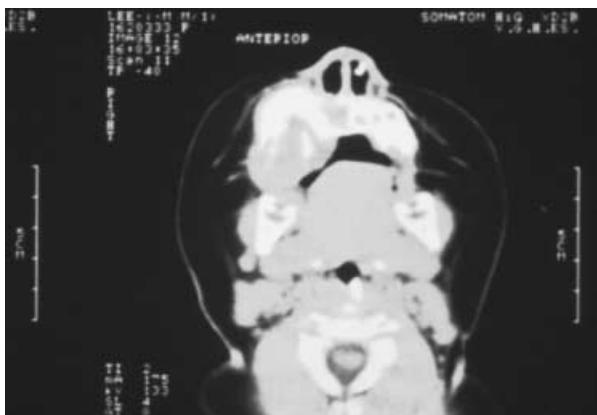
Computed tomography scan showing a soft-tissue mass arising from the right maxillary bone with bony destruction, extending upward to the infra-temporal fossa.
